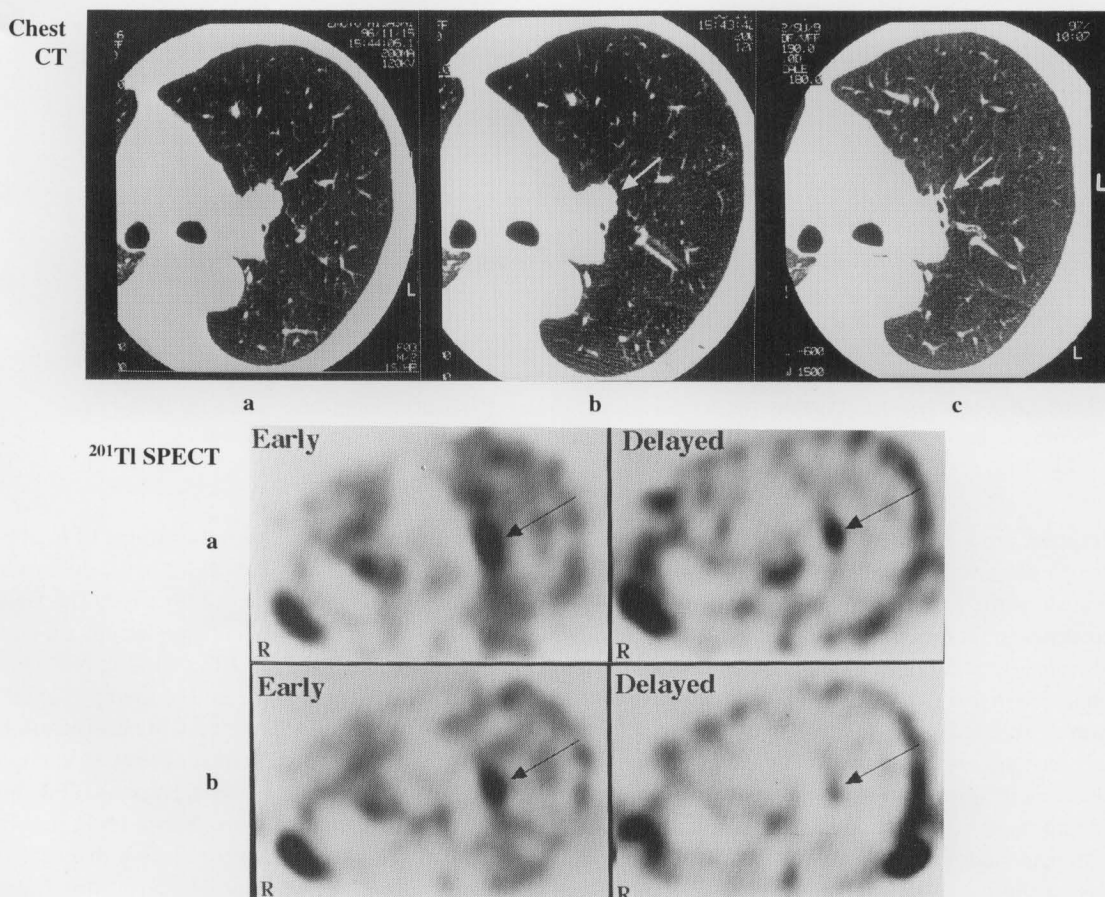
Chest CT and ^{201}Tl SPECT scans in a case of complete response (CR), a 65-yr-old male with squamous cell carcinoma (# 1 in Table 1). Chest CT scan showing a tumor measuring 23×24 mm in the left hilum before radiationtherapy (a; arrow). At an accumulated tumor dose of 22 Gy, the tumor size had not changed noticeably (b; arrow); however, it completely disappeared 19 weeks after the end of radiationtherapy with a total dose of 54 Gy (c; arrow). On ^{201}Tl SPECT, delayed uptake ratio (DUR) and retention index (RI) in the tumors (arrows) were decreased at the time of 22 Gy-dose (b) compared to pretreatment (a) (DUR; from 3.7 to 2.6, RI; 12.7% to -40.0%).
